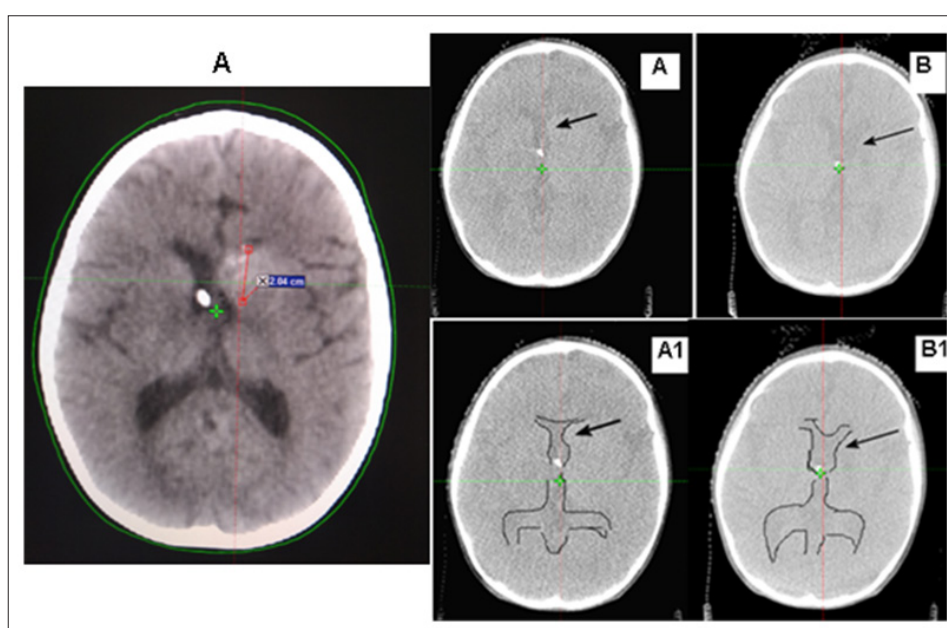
A/B: Comparison between the CB/CT Verification Images on the first day of Irradiation with the one on the Last Day, which Shows a Visible Reduction of the Nodular Lesion in the Area of the Left Caudate Nucleus. A1/B1- For better Visibility, the Lateral Ventricles are Outlined, and the Black Arrow Points to the Reduction of the Caudate Nucleus.
